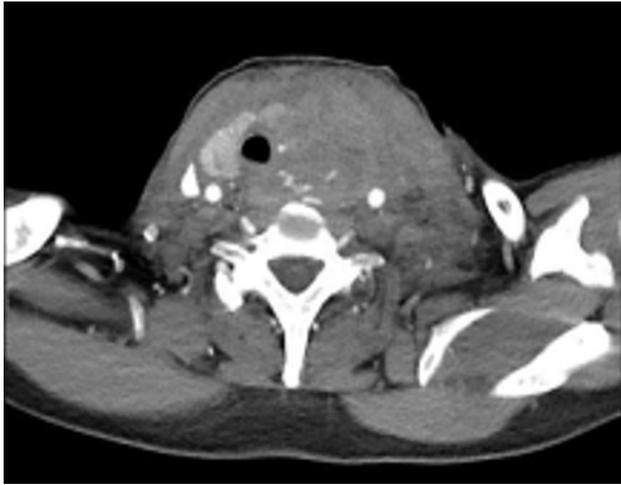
Computed tomography of the neck shows the rupture of the left lobe of thyroid gland, the large hematoma and the deviation of the trachea (sagittal view)
